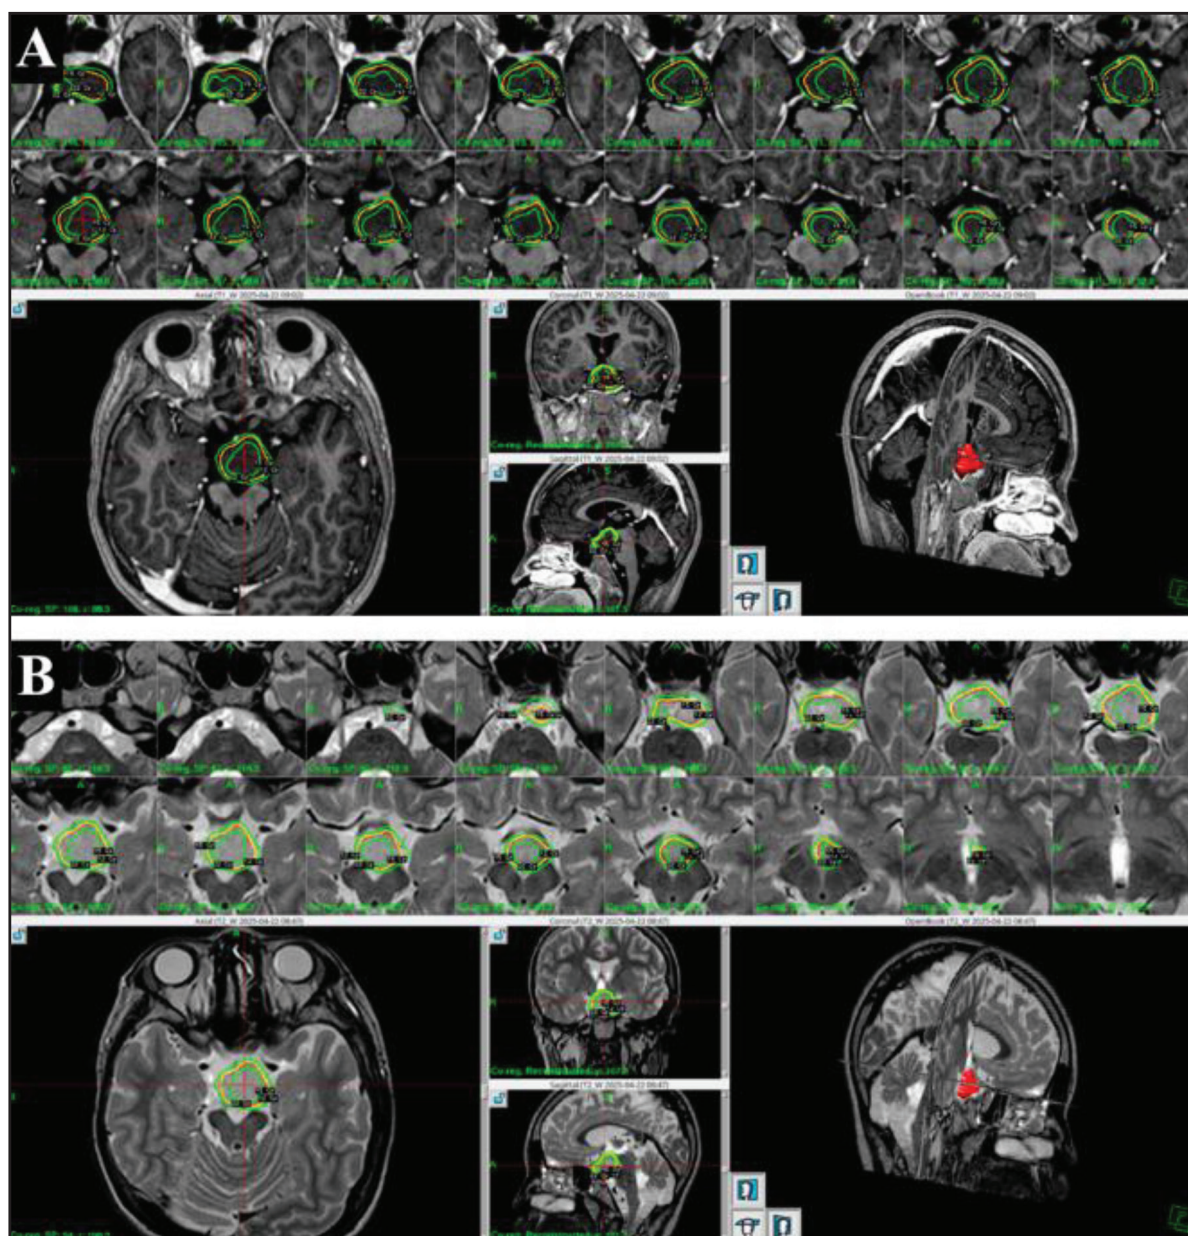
Pre-GKRS MRI of Case 3. Axial T1-weighted (A) and T2-weighted (B) images demonstrating a HH with a target volume of 5.752 cm³ before radiosurgical treatment.
